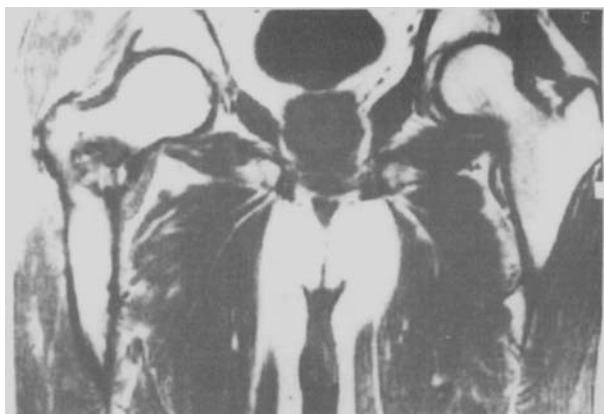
Demonstrating a tumor mass localized in the right intertrochanteric area producing cortical and medullary damage with protrusion into the surrounding soft tissues by MRI.
